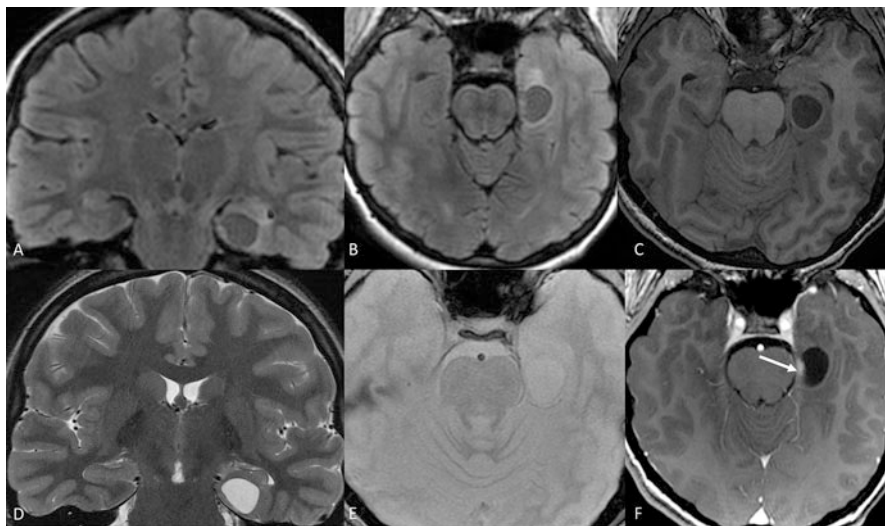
A 22-year-old male patient with intractable left temporal epilepsy. Coronal and axial FLAIR (a, b), axial T1 (c), coronal T2 (d), T2* (e), and axial T1 with contrast media (f) show a mixed cystic and solid cortical mass. The nodular portion presents with mild enhancement (arrow)
